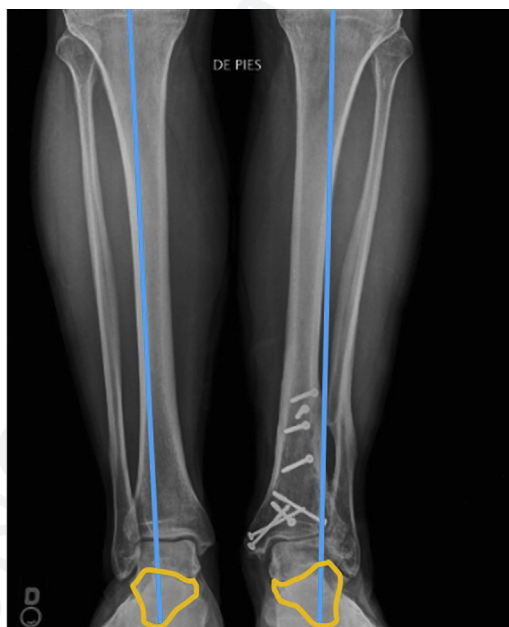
AP weight-bearing leg radiographs, in which an old distal tibia fracture can be noted on the left leg (*right side of the image*). Note the intraarticular valgus alignment of the talus, owing to an asymmetric posttraumatic ankle arthrosis where more damage was sustained on the lateral aspect of the joint. The mechanical axes are drawn on each leg for comparison (*blue lines*), and the calcaneus silhouettes are depicted as orange lines. Note the lateralization of the weight-bearing axis of the left leg, where the blue line crosses the ankle joint at the level of the tibiofibular joint.
